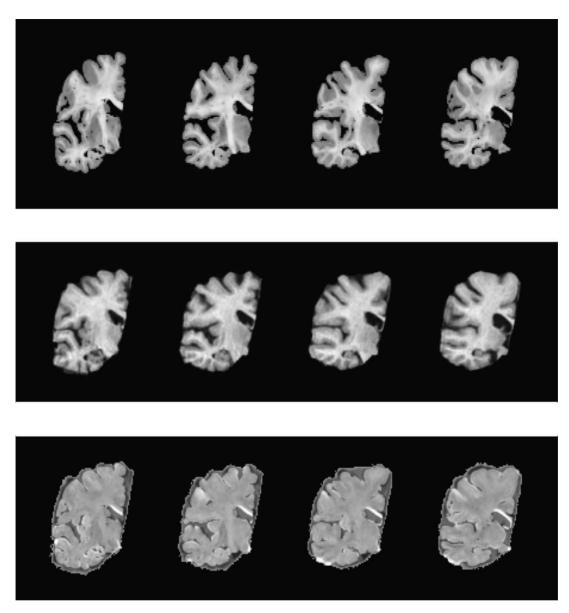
Top: four consecutive postmortem brain slices from a 92-year-old female. Middle: slices from MRI performed 1.5 years prior to death registered using PCC + MI. Bottom: top images subtracted from middle images to give difference images (top) minus (middle).
